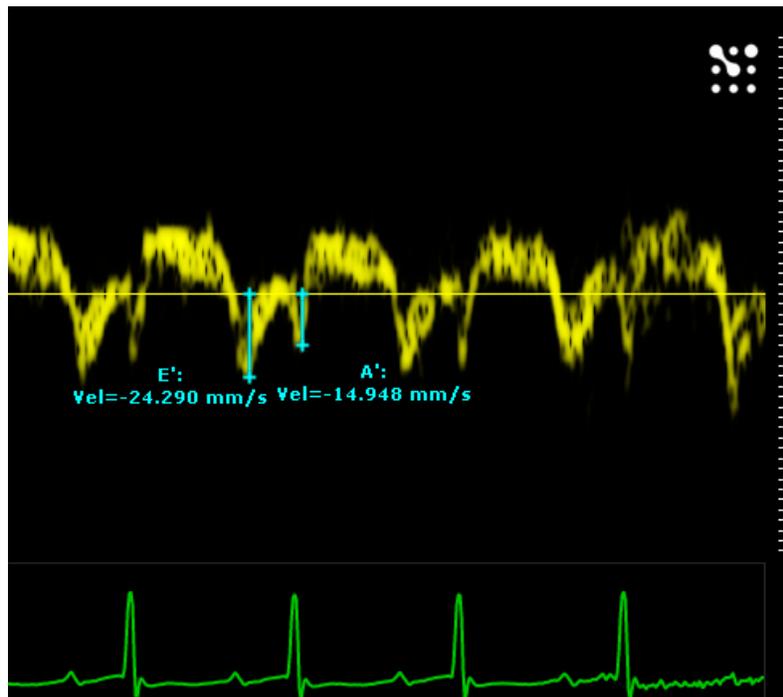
PW Tissue Doppler Cardiac package with the list of available protocols
